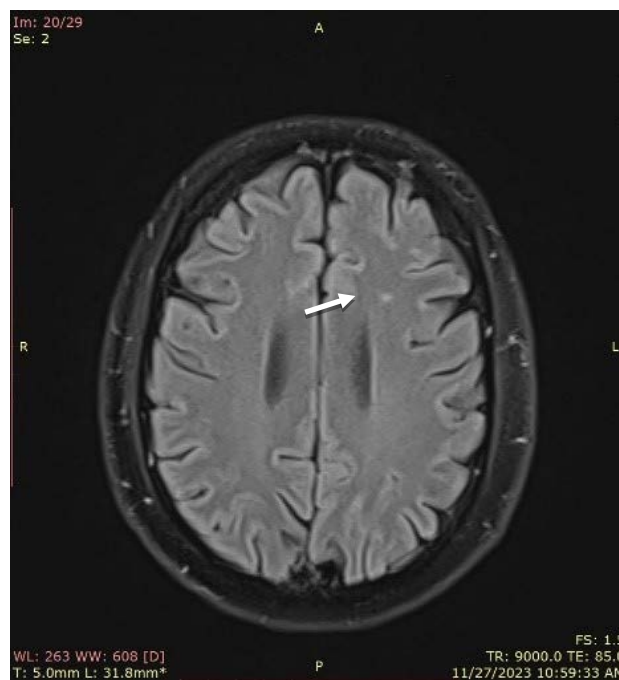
Magnetic resonance imaging shows two isolated chronic micro-ischaemic brain lesions.
